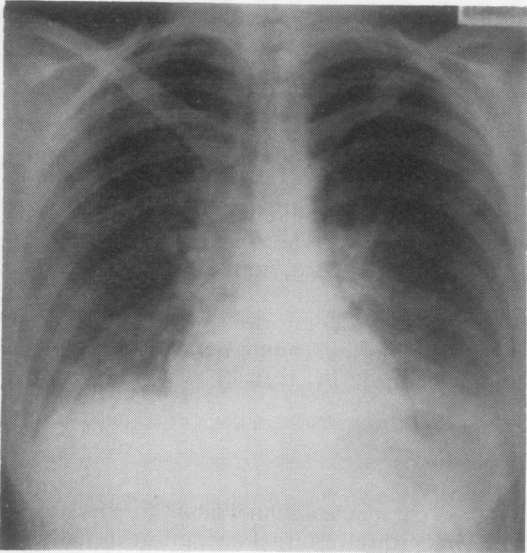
Chest radiograph 17 hours after challenge to Pauli's reagent showing bilateral diffuse small nodular opacities.
